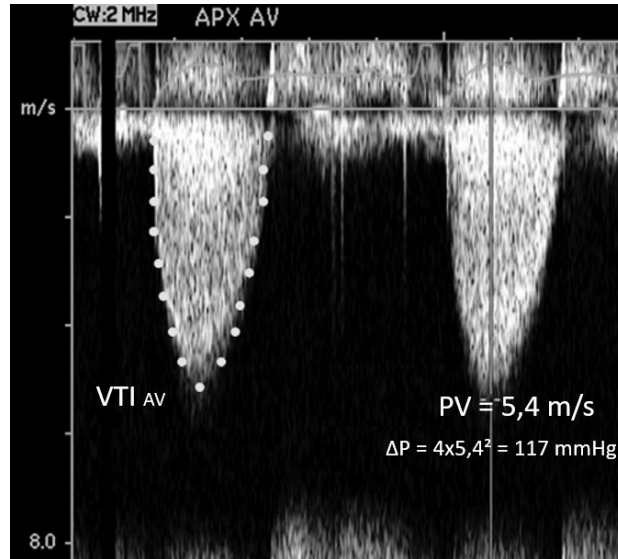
Continuous-wave Doppler recording of a maximum jet velocity (PV) of 5.4 m/s in AS. VTI AV= velocity time integral through the aortic valve. Adapted from Baumgartner et al. J Am Soc Echocardiogr 2009;22:1-23; quiz 101-2 ⁽¹⁷⁾.
